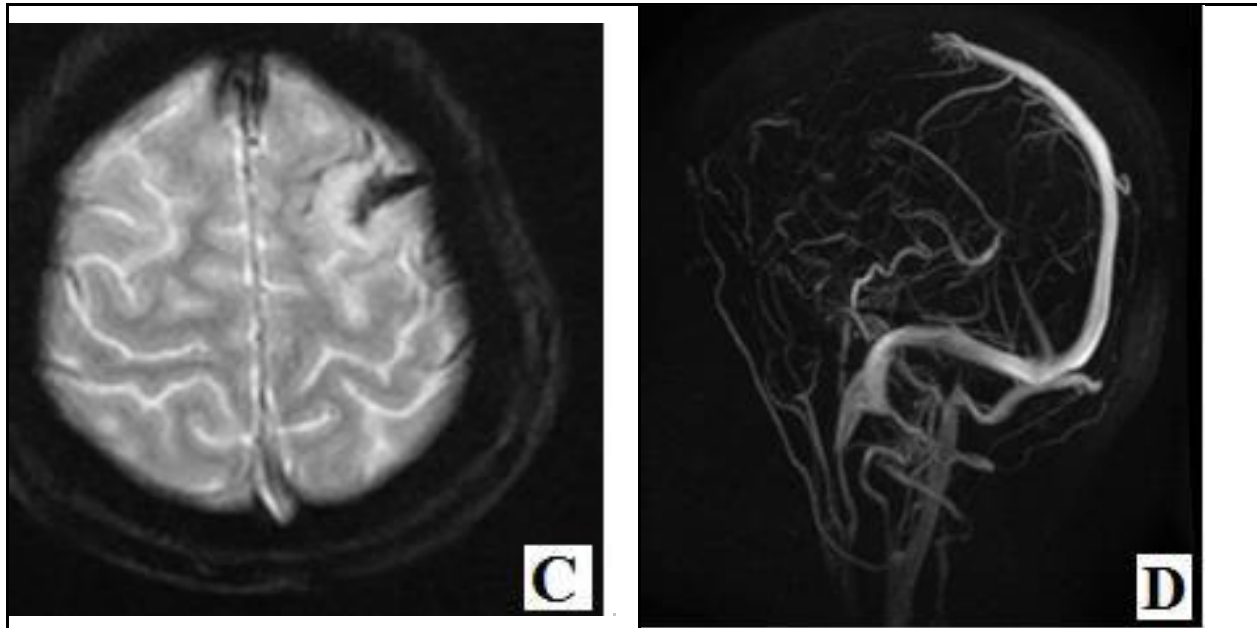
Representative Case: Coronal T2W and DWI images showing loss of flow void in superior sagittal sinus, acute infarct in left frontal lobe. Axial T2* image showing blooming artifacts indicating hemorrhagic infarct. 2DTOF MIP image showing absence of flow in the anterior half of superior sagittal sinus.
